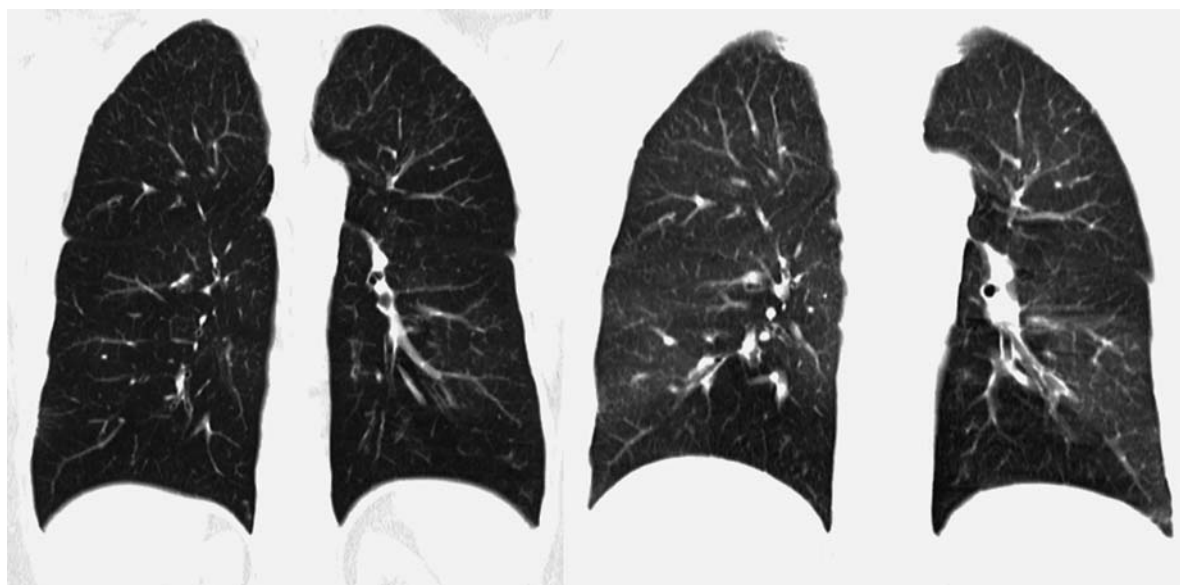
Coronal multiplanar reformation CT section of a double-lung transplantation recipient in inspiration (*left*) and expiration (*right*). Whereas lung density in inspiration is normal, expiration shows extensive basal air trapping
